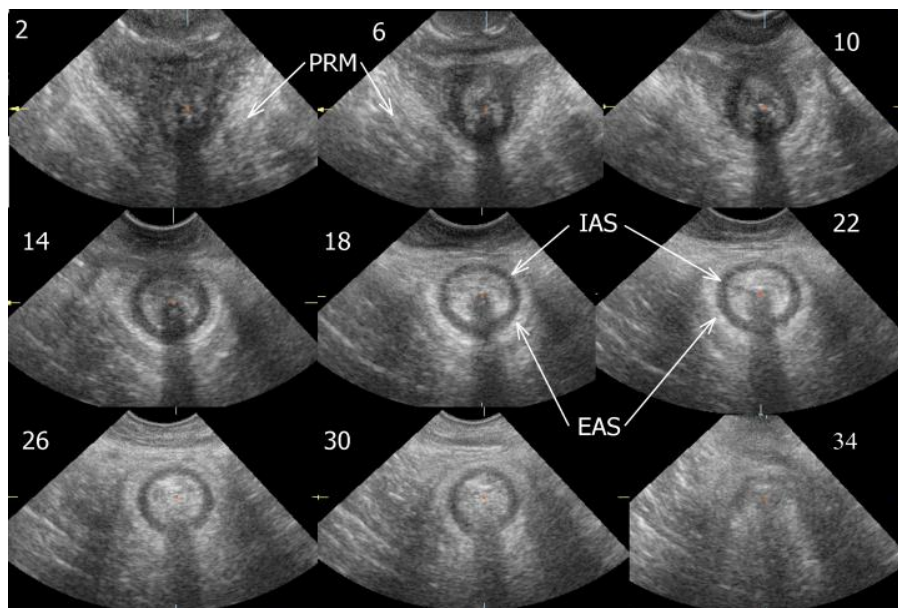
Transverse section view of anal canal seen on ultrasound at every 4 mm distance. Reproduced by permission from Nature Publishing Group.
